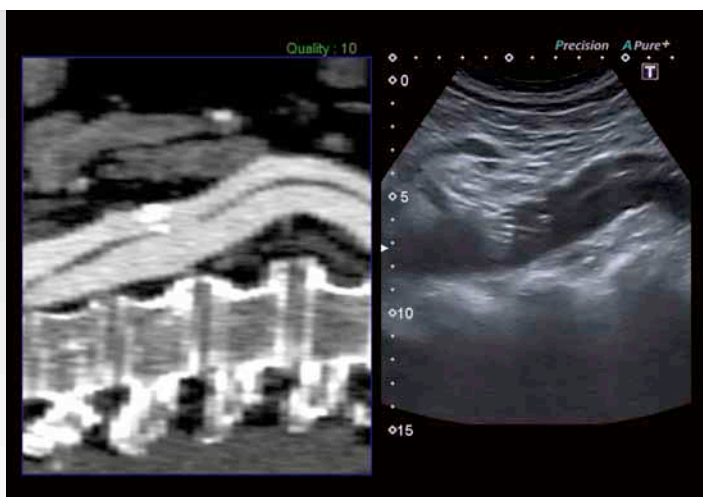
Smart Fusion, B-mode: The left side of the dual screen monitor shows the sagittal image of the CTA dataset stored on the US system. The corresponding B-mode image is shown on the right. The end of the stent that projects into the true lumen is visible as an echo-rich artefact. The dissection membrane is visible as a thin, echo-rich strip in the aortic lumen.
